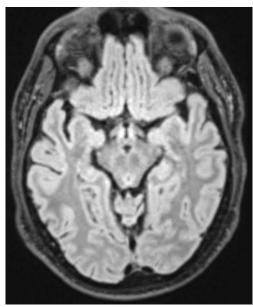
This is a normal magnetic resonance image of the brain. There is no blood in the perimesencephalic area.
